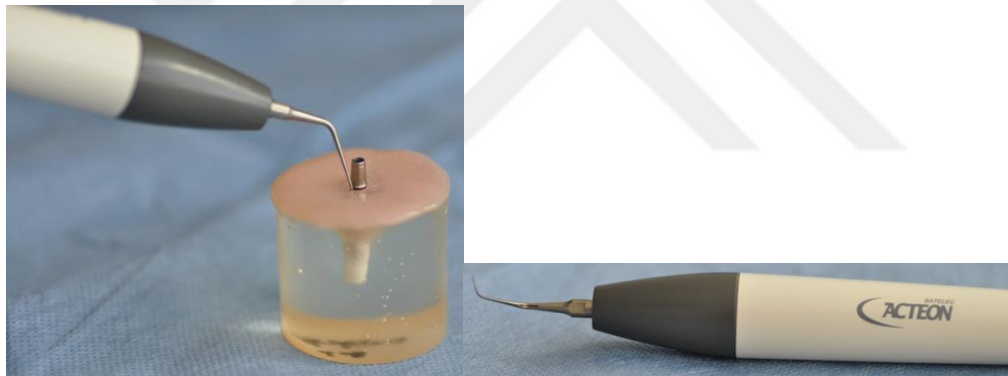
Instrumentation with an ultrasonic device with special designed tip
